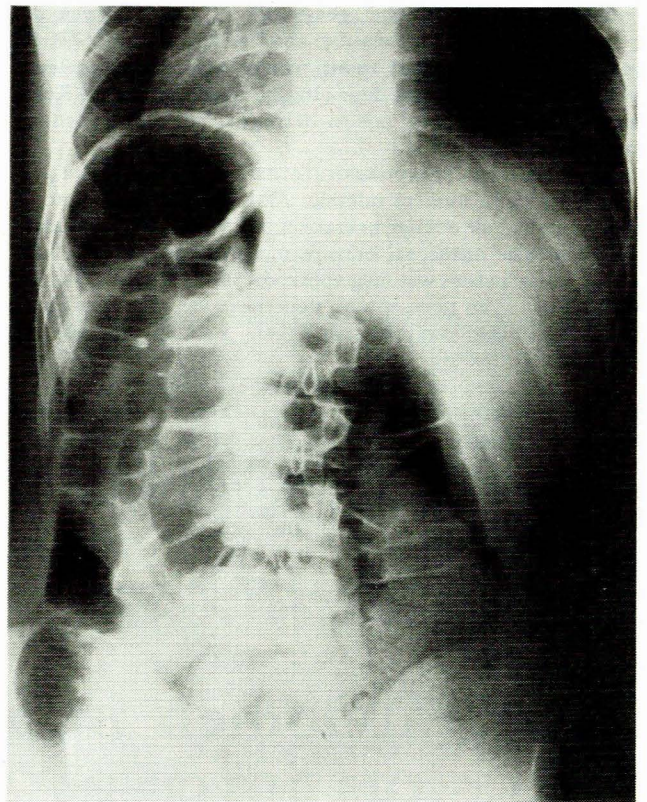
Abdominal radiograph. The presence of a left-sided liver shadow together with dextrocardia confirms the diagnosis of complete situs inversus.
